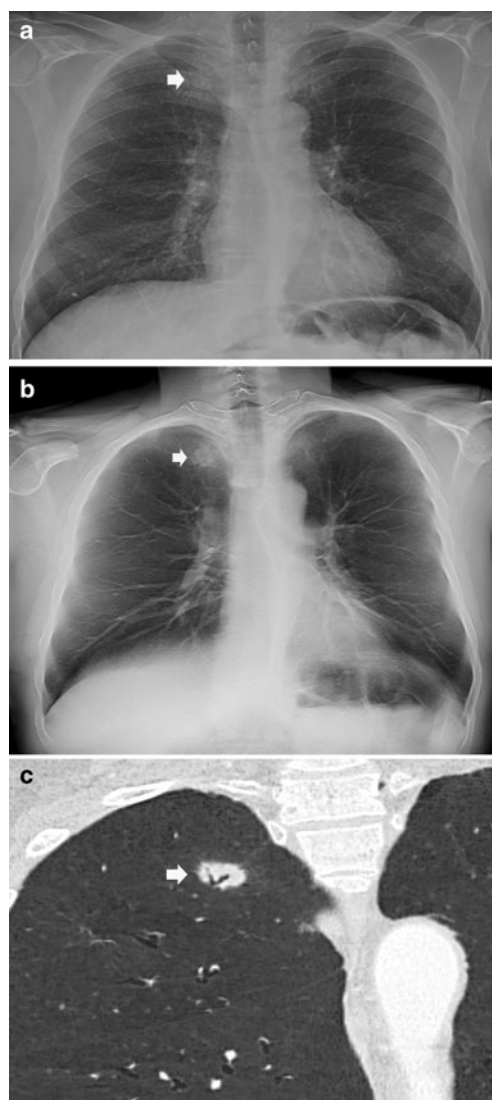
A 65-year-old man with a peripheral pulmonary ground-glass pulmonary nodule. a Posteroanterior chest radiography in the upright position shows one suspected pulmonary opacity of the apex of the right lung (*arrow*) behind the overlying anterior arch of the first right rib. b Digital tomosynthesis planes show a ground-glass pulmonary nodule (*arrow*) with evidence of intralobular air bronchogram. c CT image (lung window, coronal reformation) confirms the same opacity with a similar feature as shown by digital tomosynthesis
